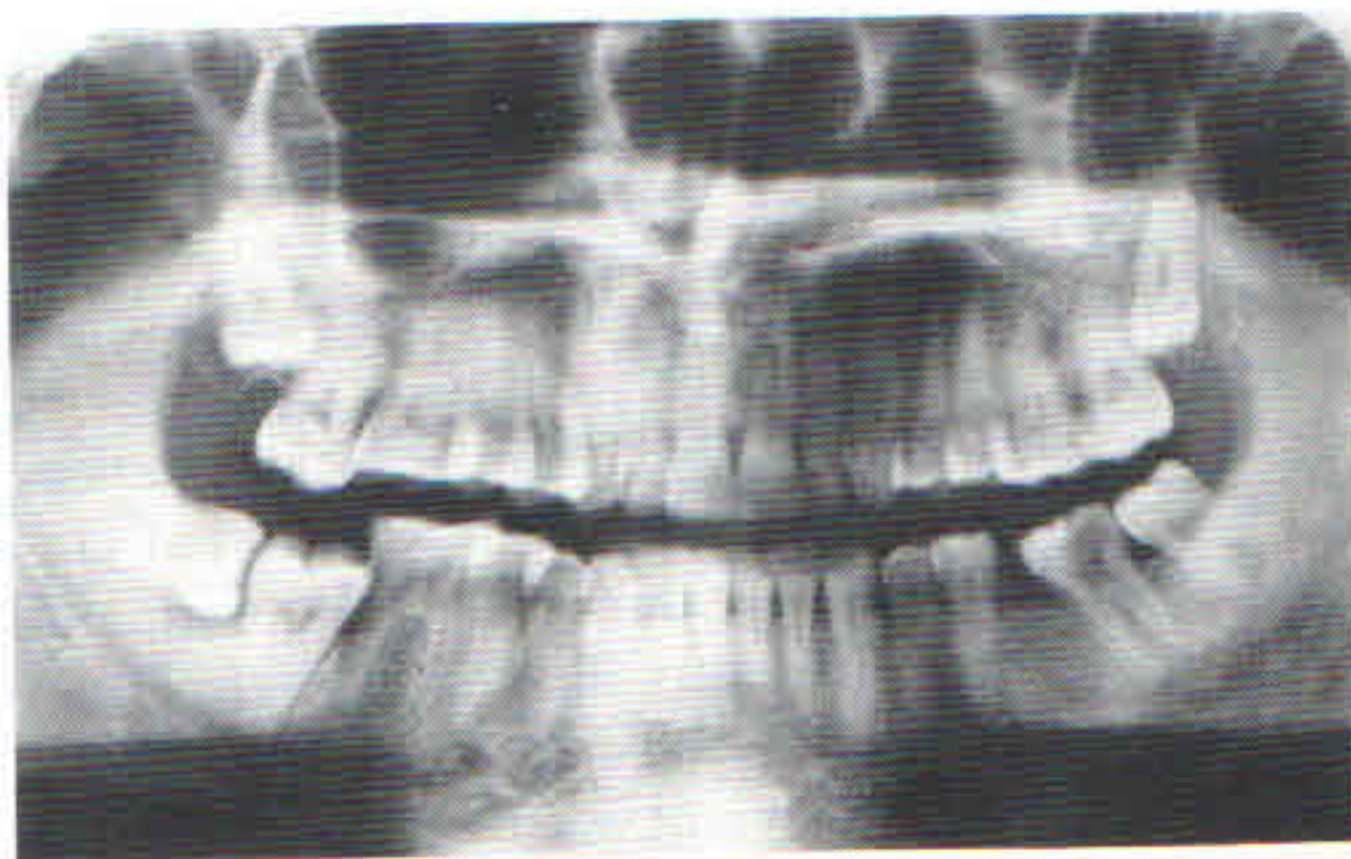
Orthopantomogram shows the position of the right second and third molar teeth in relation to the occlusal plane.
